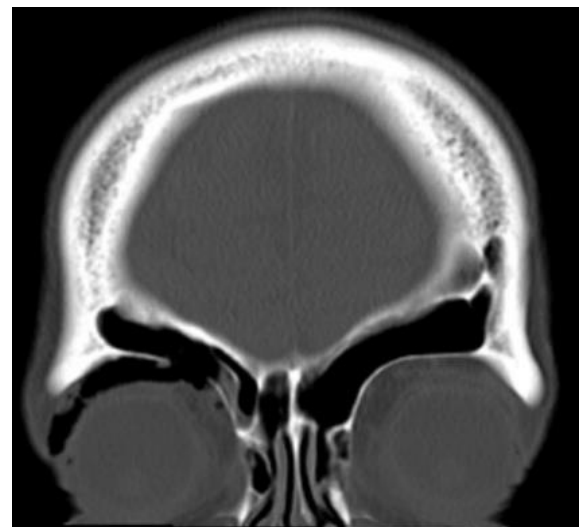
Coronal view of the CT bone window showing a displaced bone fragment in the right frontal sinus.
